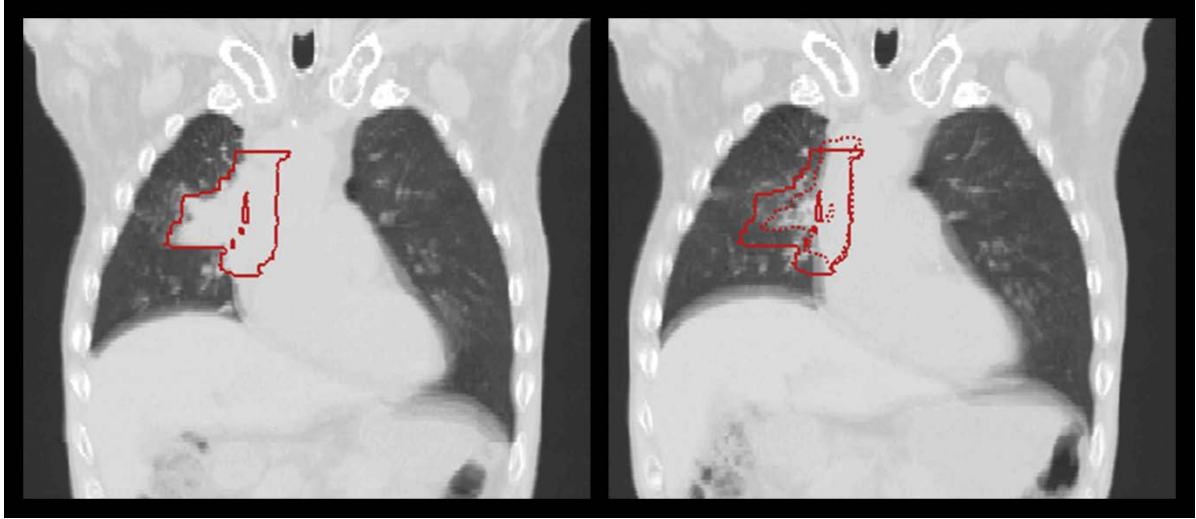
An example of a lung patient with shrinking tumor size due to response to treatment. On the left is the anatomy from a CT scan before treatment and on the right is the anatomy from a CT scan after 6 weeks of treatment. The GTV is displayed in red with the solid lines showing the original GTV and the dotted lines showing the new GTV on the 6<sup>th</sup> week of treatment.
